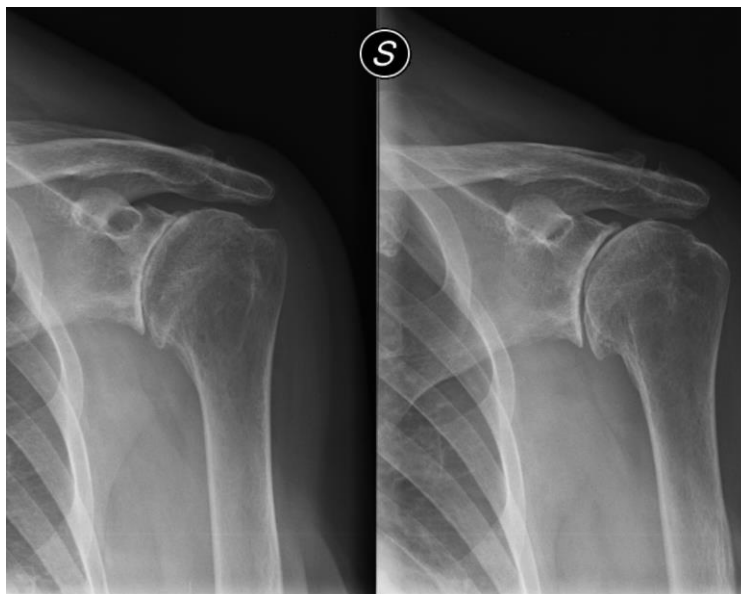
Radiograph obtained few days before the first medical appointment.
